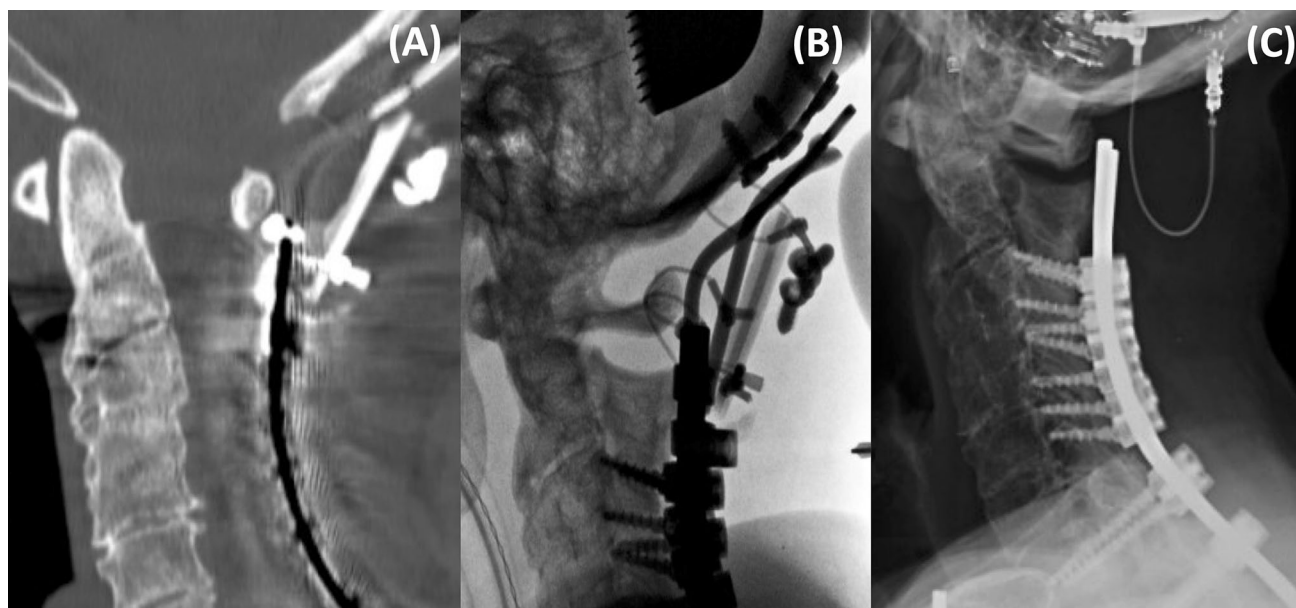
One year postoperatively, the patient complained of new onset pain in the posterior occipital area. A cervical CT scan (a) and cervical radiographs (b) demonstrated healed odontoid and pars fractures (a), a broken occipital-cervical plate (b), and no posterior
